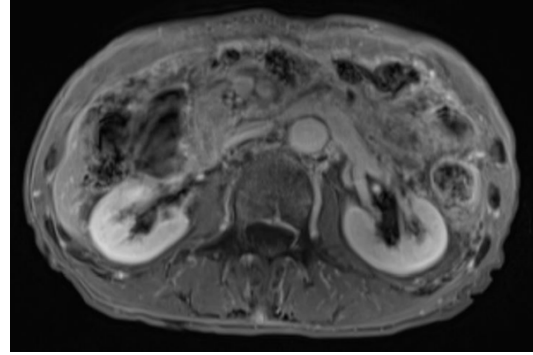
(2017-7-20) Enhanced MRI of the pancreas showed that the lesions of the head of the pancreas were larger than before.
